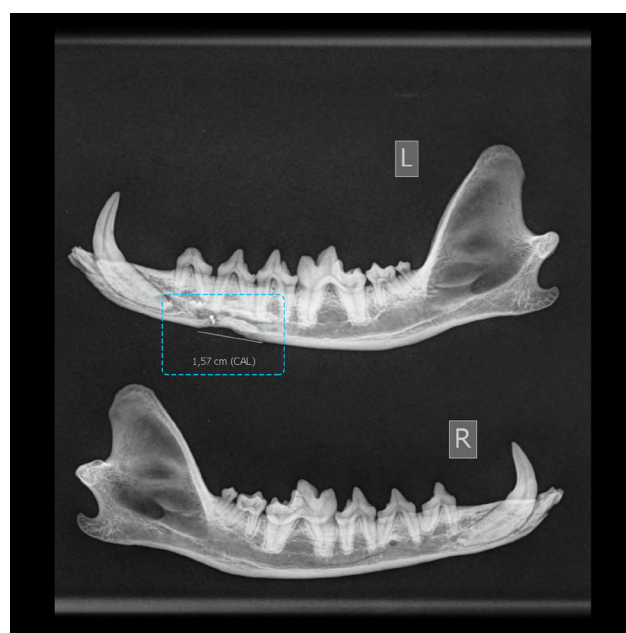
X-ray of compression fracture (marked by a square) of the left mandible of a male red fox.
